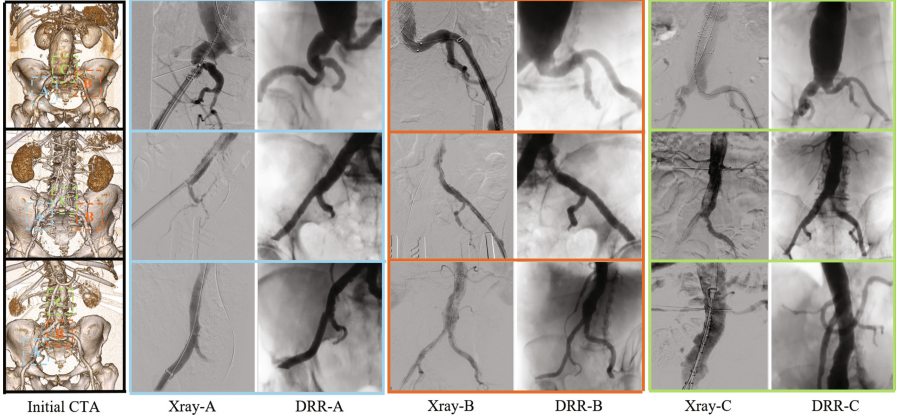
Visual comparison between real X-rays and DRRs generated from planned view poses in three patients. The locations of the comparison correspond to the 3D visualization of the CTA and are marked with different colors.
